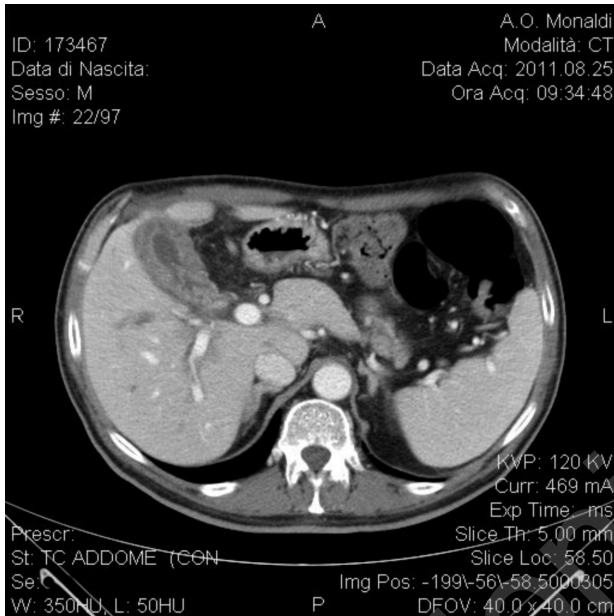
CT scan showing thickened gallbladder walls.
